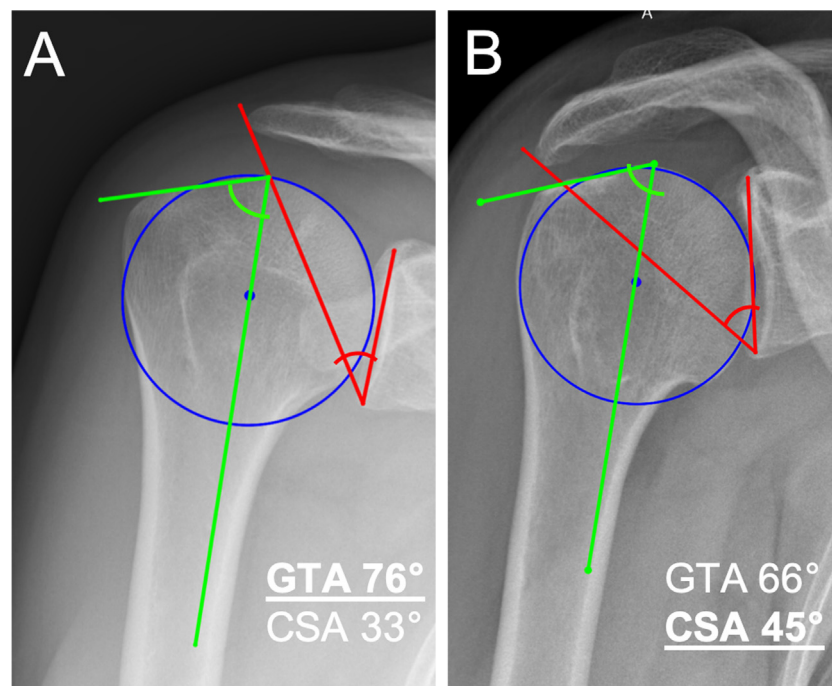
Radiographs of 2 patients with a degenerative rotator cuff tear. A. High greater tuberosity angle (GTA) and a low critical shoulder angle (CSA). B. High CSA and a low GTA.
